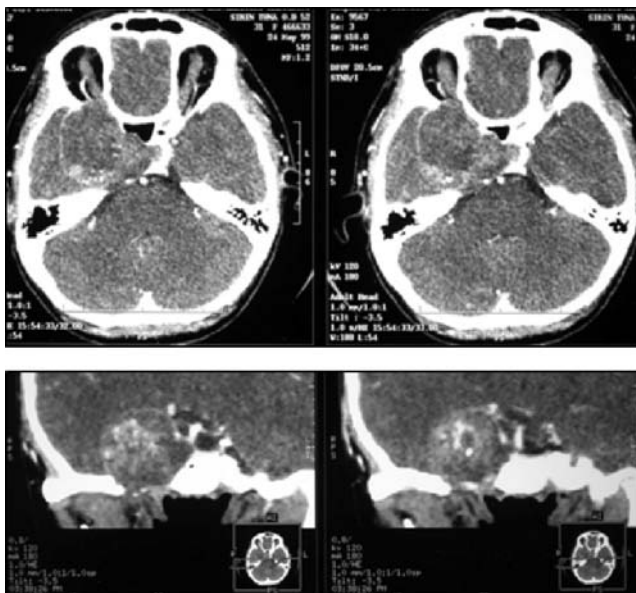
Preoperative CT and 3-dimensional CT images show bone erosion caused by a giant trigeminal schwannoma
